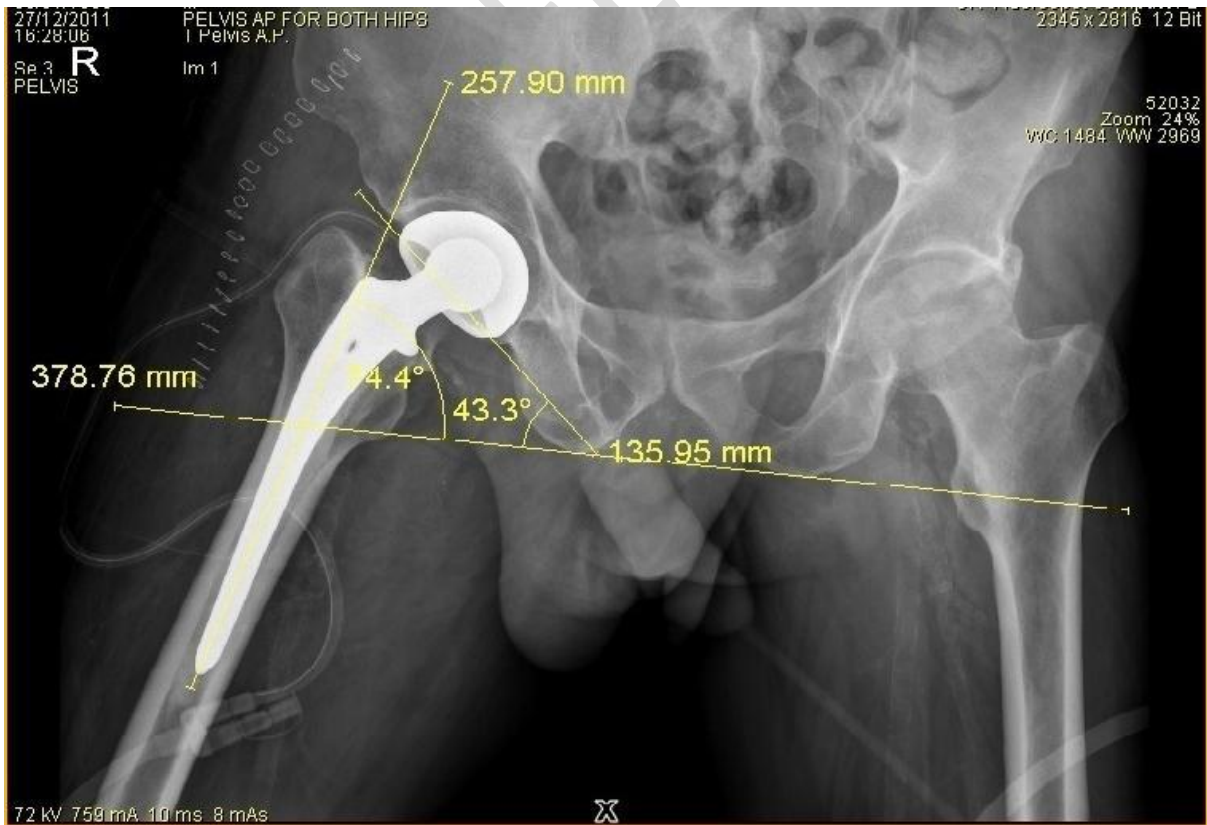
X-ray of pelvis with both hips (Abduction of operated hip) with Bipolar prosthesis on right side
